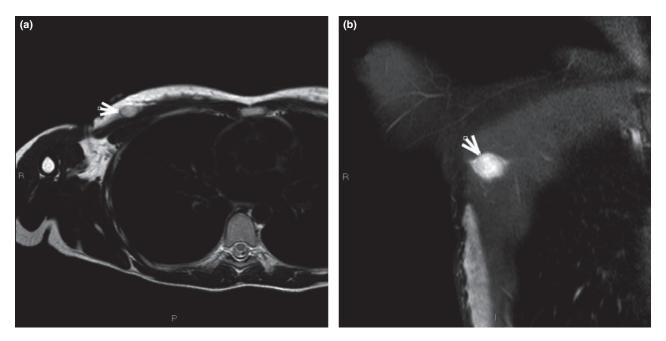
Magnetic resonance. (a) Axial T2-weighted images demonstrate a well-circumscribed mass predominantly hyperintense (white arrow). (b) Dynamic contrast-enhanced MR images in (selective partial T1 inversion recovery) showed rapid early enhancement of the mass (white arrow).
